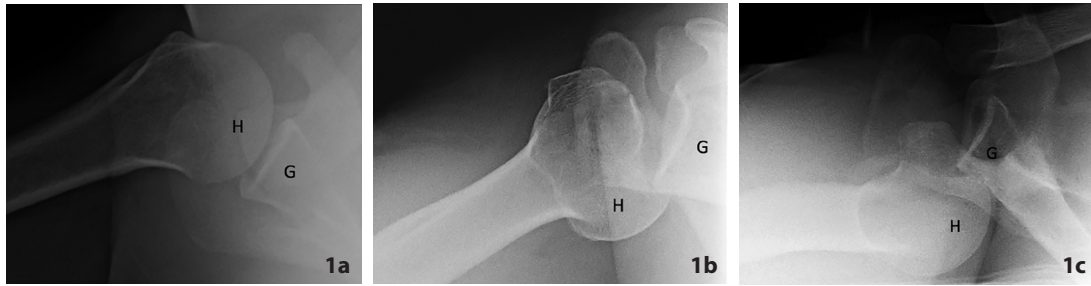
Axillary radiographs of the normal and posteriorly subluxed or dislocated glenohumeral joint. In (a) note normal anatomic alignment of the glenohumeral joint, with the humeral head well seated in the glenoid fossa compared to (b) which shows posterior subluxation of the glenohumeral joint, with the humeral head partially posteriorly displaced in relation to the glenoid, and (c) which demonstrates posterior dislocation of the glenohumeral joint, with the humeral head displaced completely posterior to the glenoid. H=humeral head, G=glenoid.
